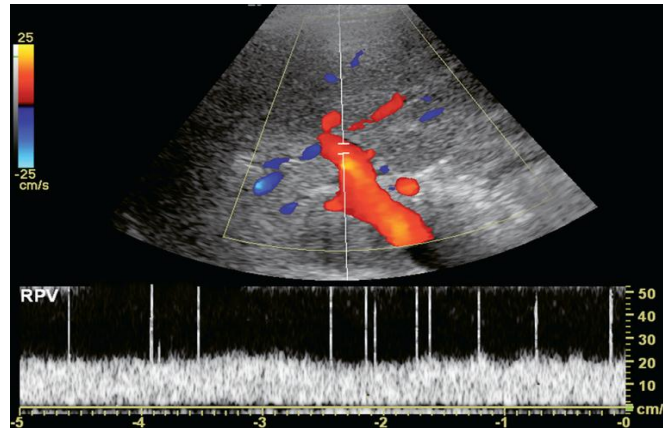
Spectral Doppler tracing of the portal vein in a patient with pneumatosis intestinalis. The spikes present in this spectral Doppler tracing are caused by air bubbles in the portal vein. These bubbles are travelling at the same velocity as the rest of the blood in the portal vein, but with the spectral gain set for blood, the intense sound reflection caused by the passing air bubbles creates spikes of noise. (Myron A. Pozniak et al, 2014)
